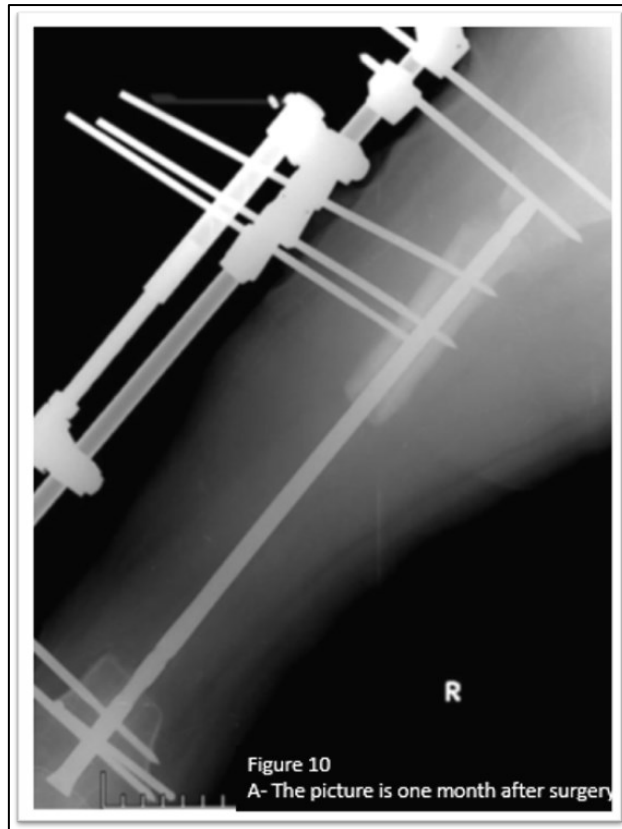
X-ray One Month Post-Second Surgery
